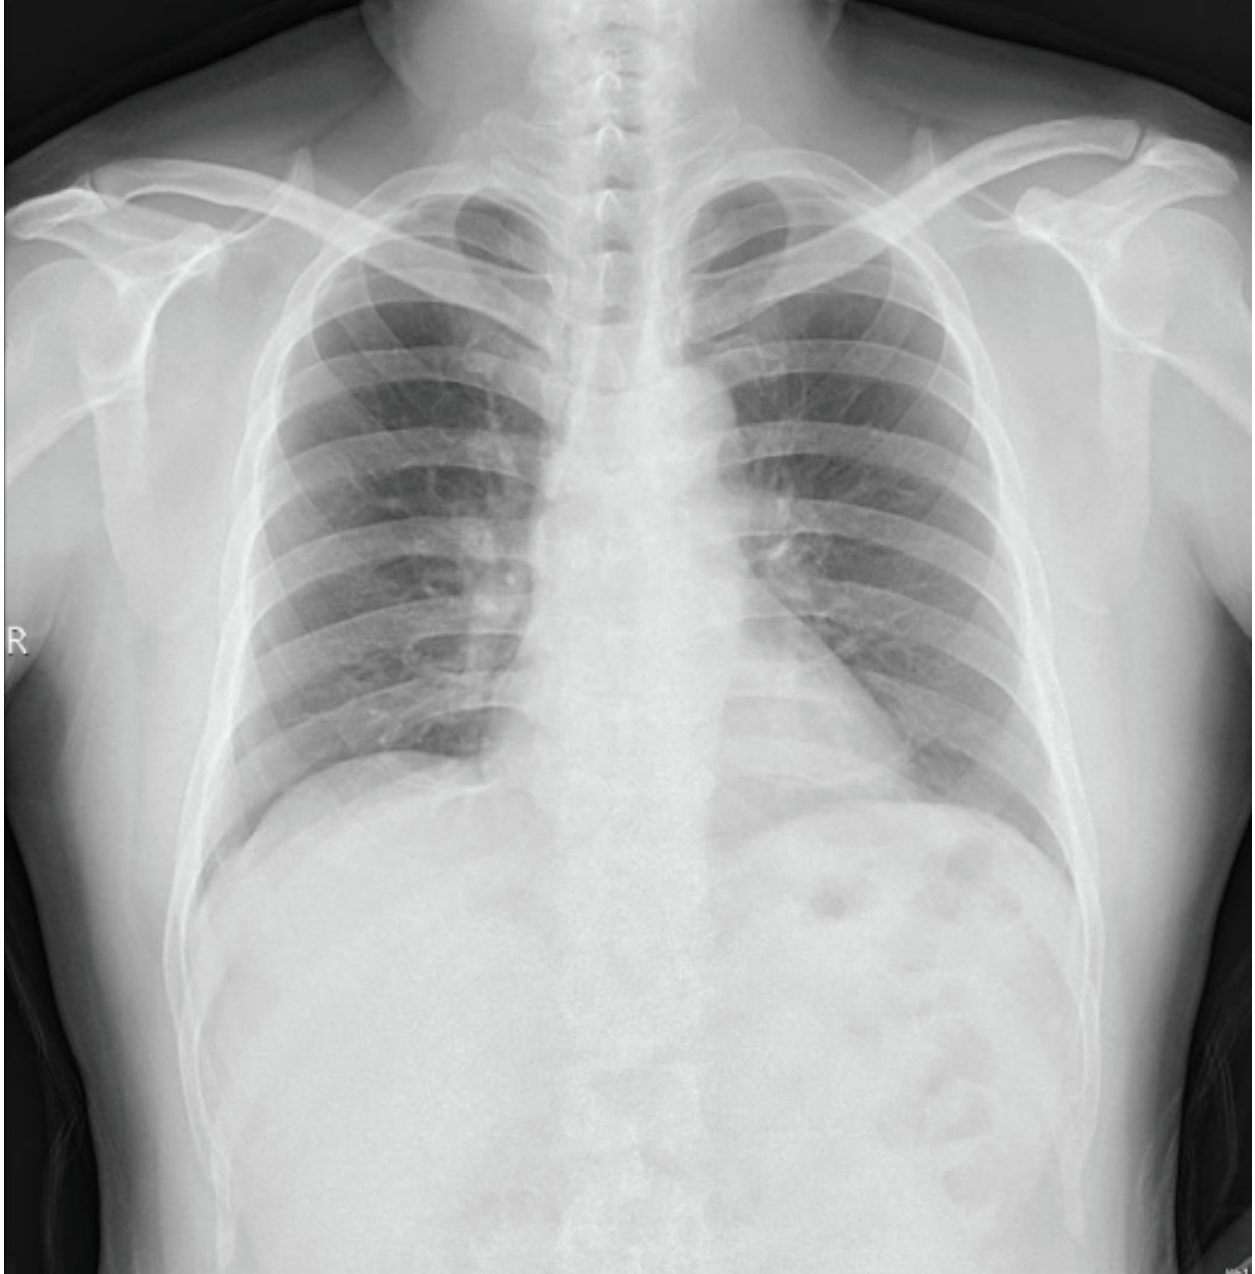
Chest X-ray film of patient 2. The chest X-ray result of patient 2 was unremarkable.
